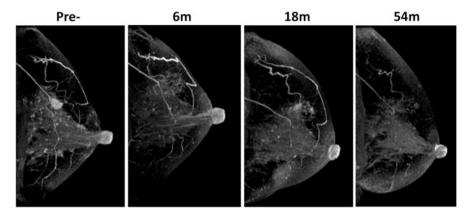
A case of average postoperative progress on MRI (as of September 2013)
